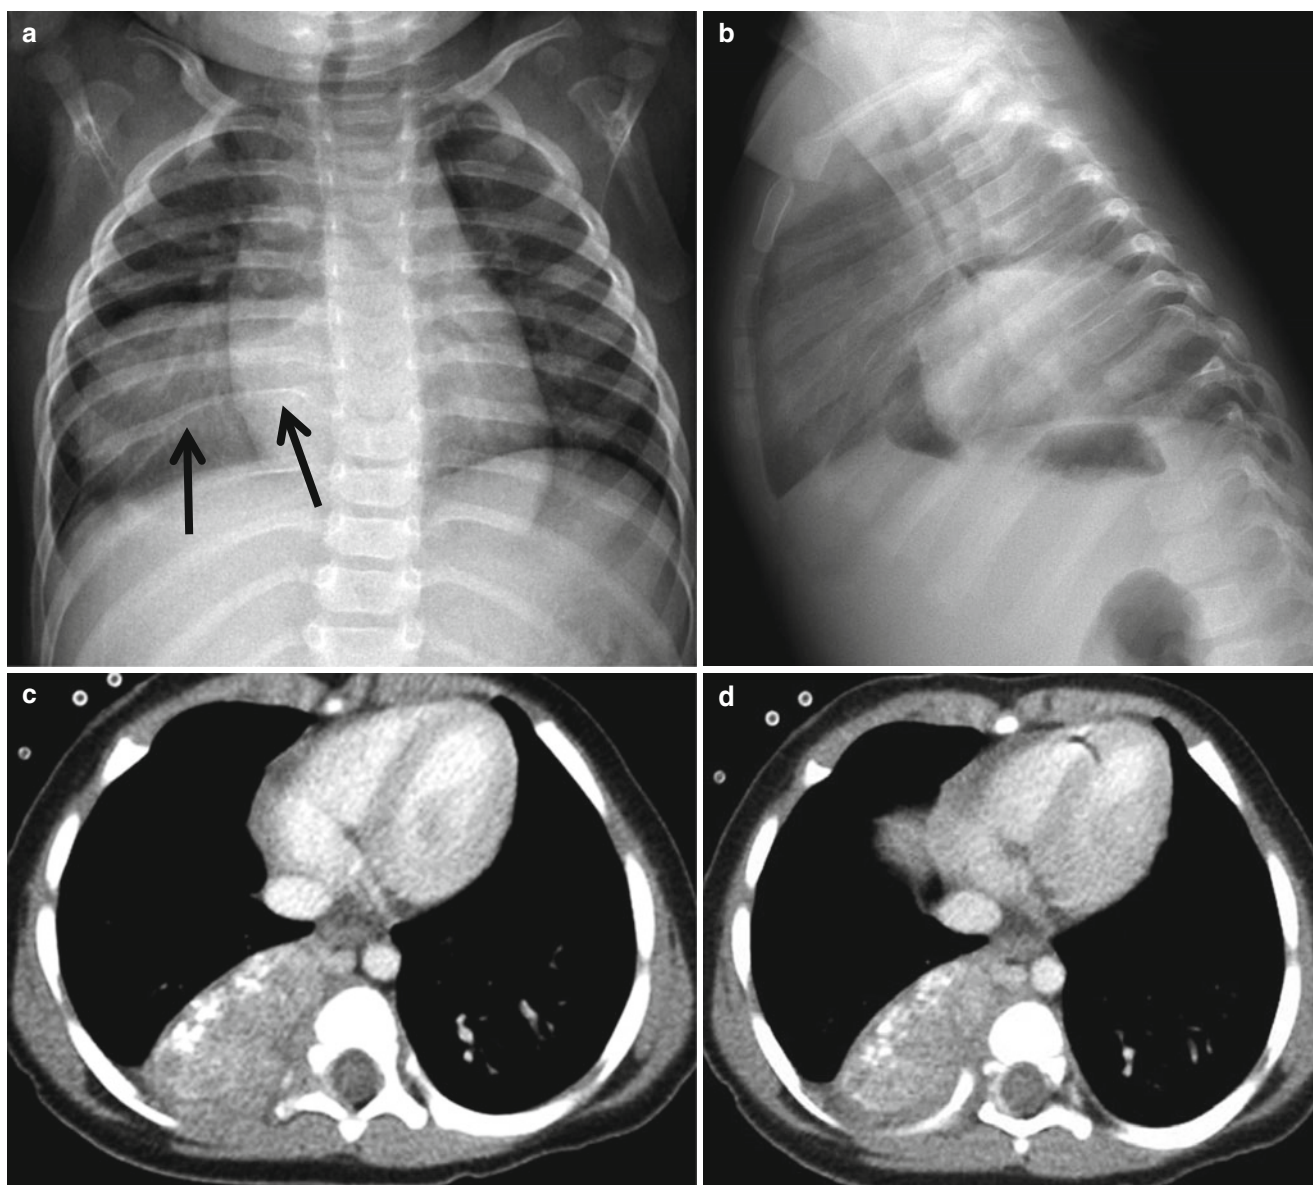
Thoracic neuroblastoma with intraspinal extension in an 11-month-old girl with fever. (a, b) Frontal and lateral radiographs show a large opacity in the right lower zone, causing posterior rib erosion and distortion (*arrows*). (c, d) Contrast-enhanced axial CT shows a calcified
